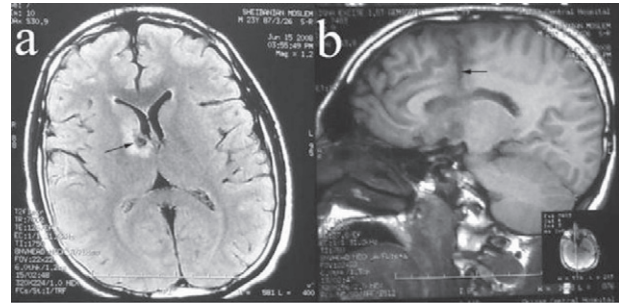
Unenhanced brain MRI of the patient. [a] Axial view shows a small contusion with surrounding edema. [b] Right parasagittal view shows a hypointense line probably indicative of the tract created by the sharp instrument.
